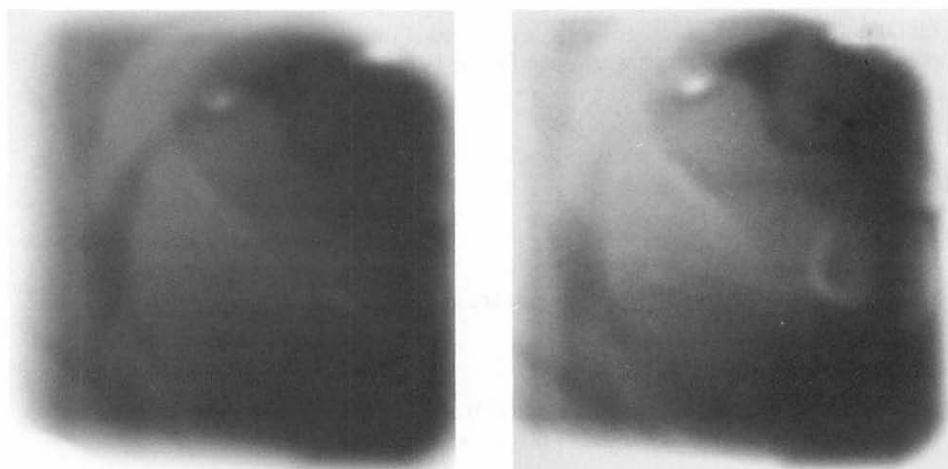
Co-60 conventional (a) and digital (b) portal film of a lateral oropharynx field. Whereas the overall image quality is comparable with both techniques, the penumbra area on the computed radiography image on the right (b) is irregularly diminished because of the digital enhancement technique.
